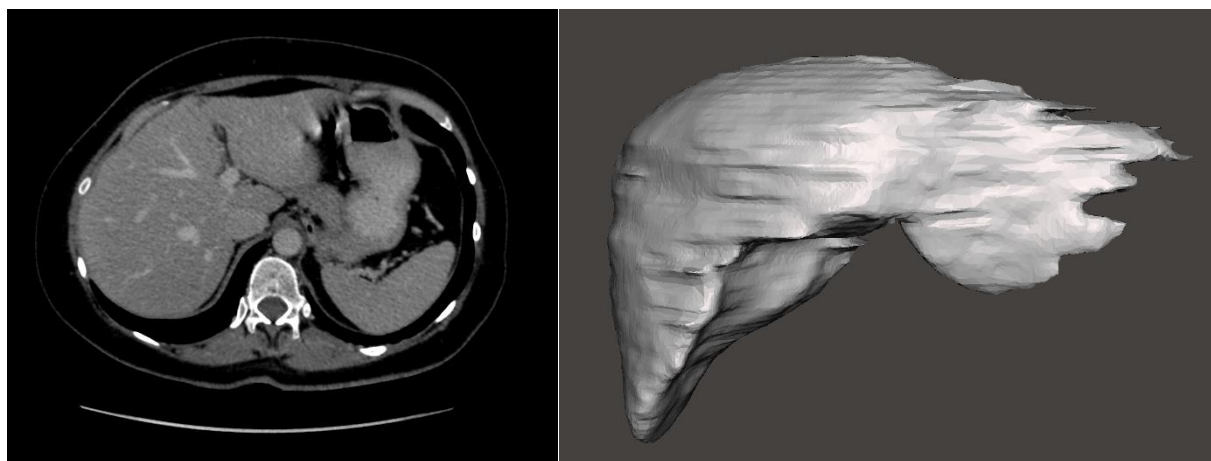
CT scan (left) can be converted into three-dimensional STL models (right) using computer-aided approach. The level of detail can be adjusted and several anatomical structures may be removed to get final, simplified model. Image on the right show liver without any vessels, so that the plastic liver could be used for tactile teaching young VI students about major organs size, location and structure.
